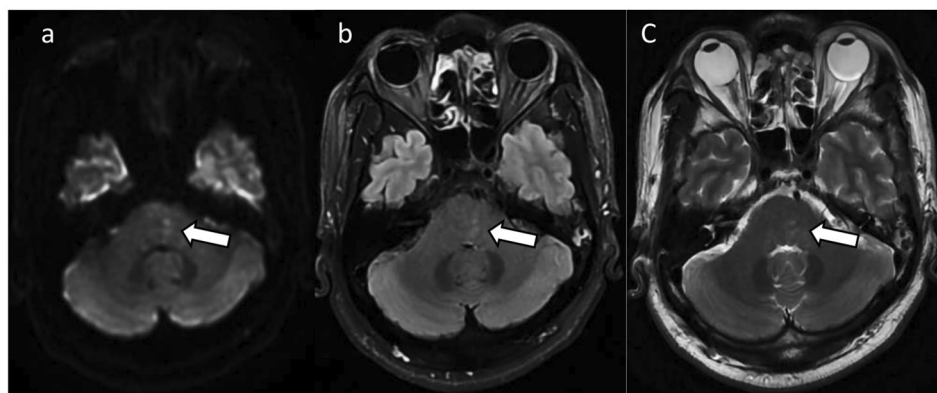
On the 9th day after onset MR re-examination revealed a slightly enlarged area of restricted diffusion (arrow) extending ventrally along the midline in the pons (a), with high signal intensity observed on T2 (b) and T2-FLAIR sequences (c)
